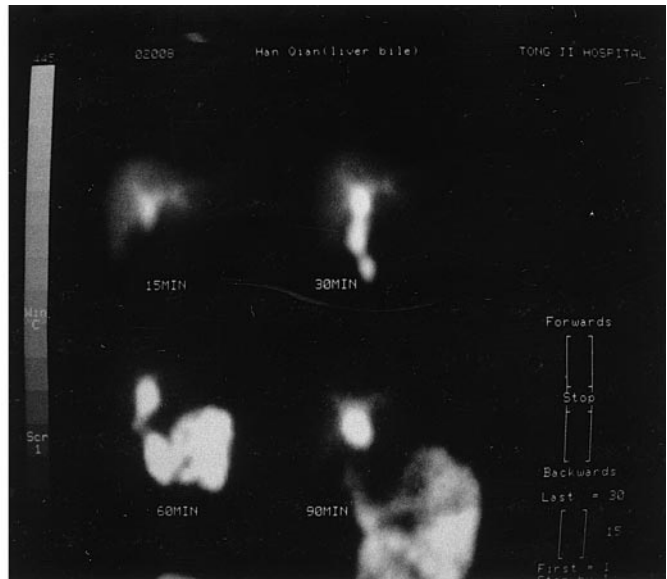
SPECT scan reveals good developing intestine and reconstructed biliary duct 6 months after operation
